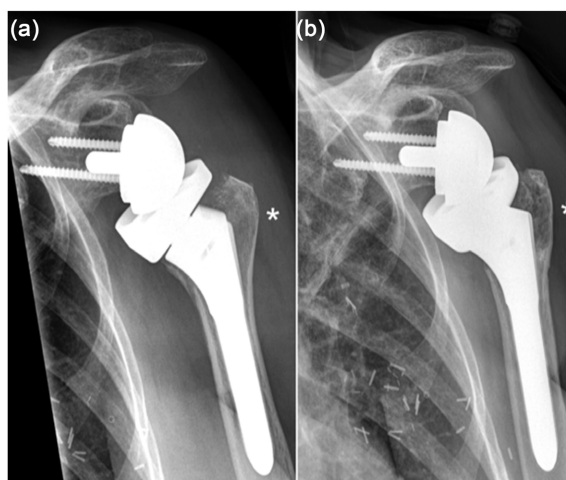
X-Rays after inverse shoulder replacement in 2021 (a) and 2023 (b) showing the increasing osteolysis in the greater tuberosity (*) caused by the growing radiation-induced osteosarcoma confirmed by biopsy.
